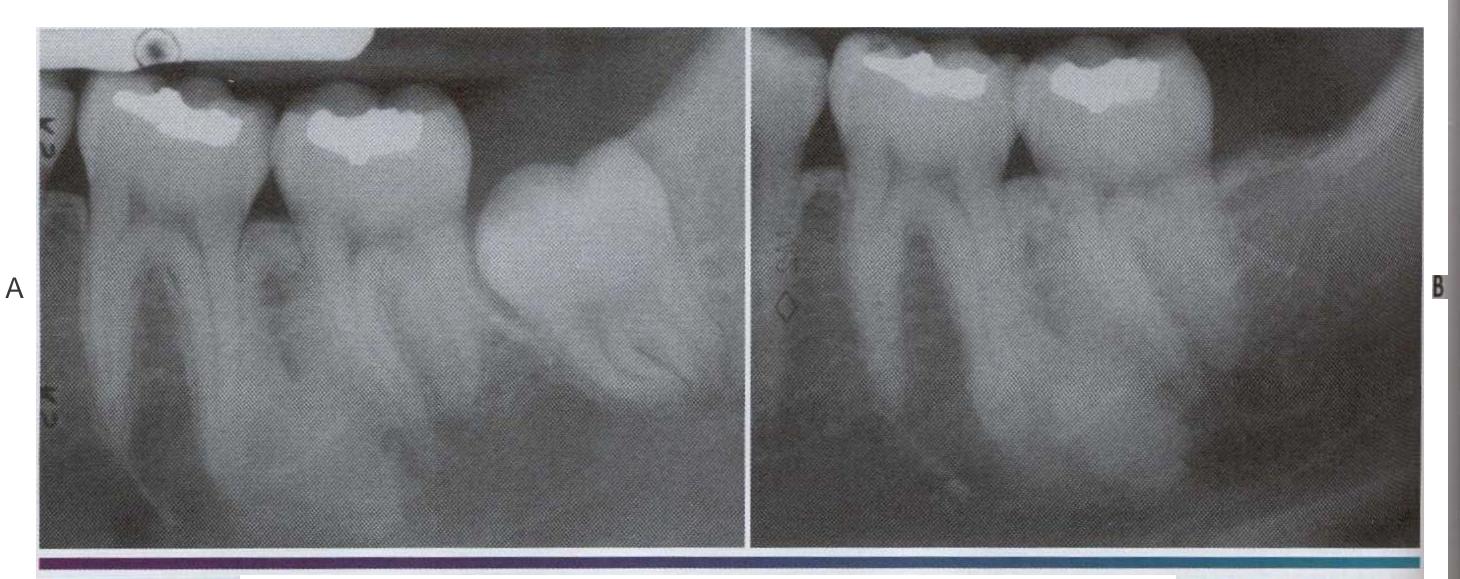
• Idiopathic osteosclerosis. A. An asymptomatic area of bane sclerosis is seen between and apical to the roots of the first and second mandibular molars. B, No appreciable change can be seen on this radiograph taken 10 years later. (Courtesy of Dr. Michael Quinn.)
